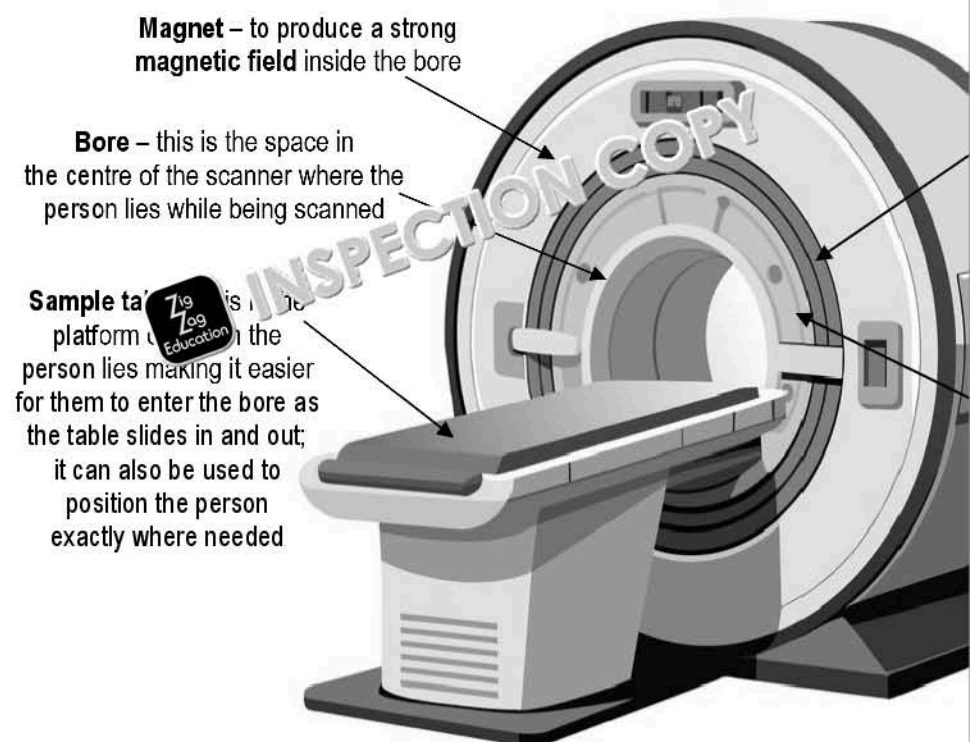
MRI machine structure
